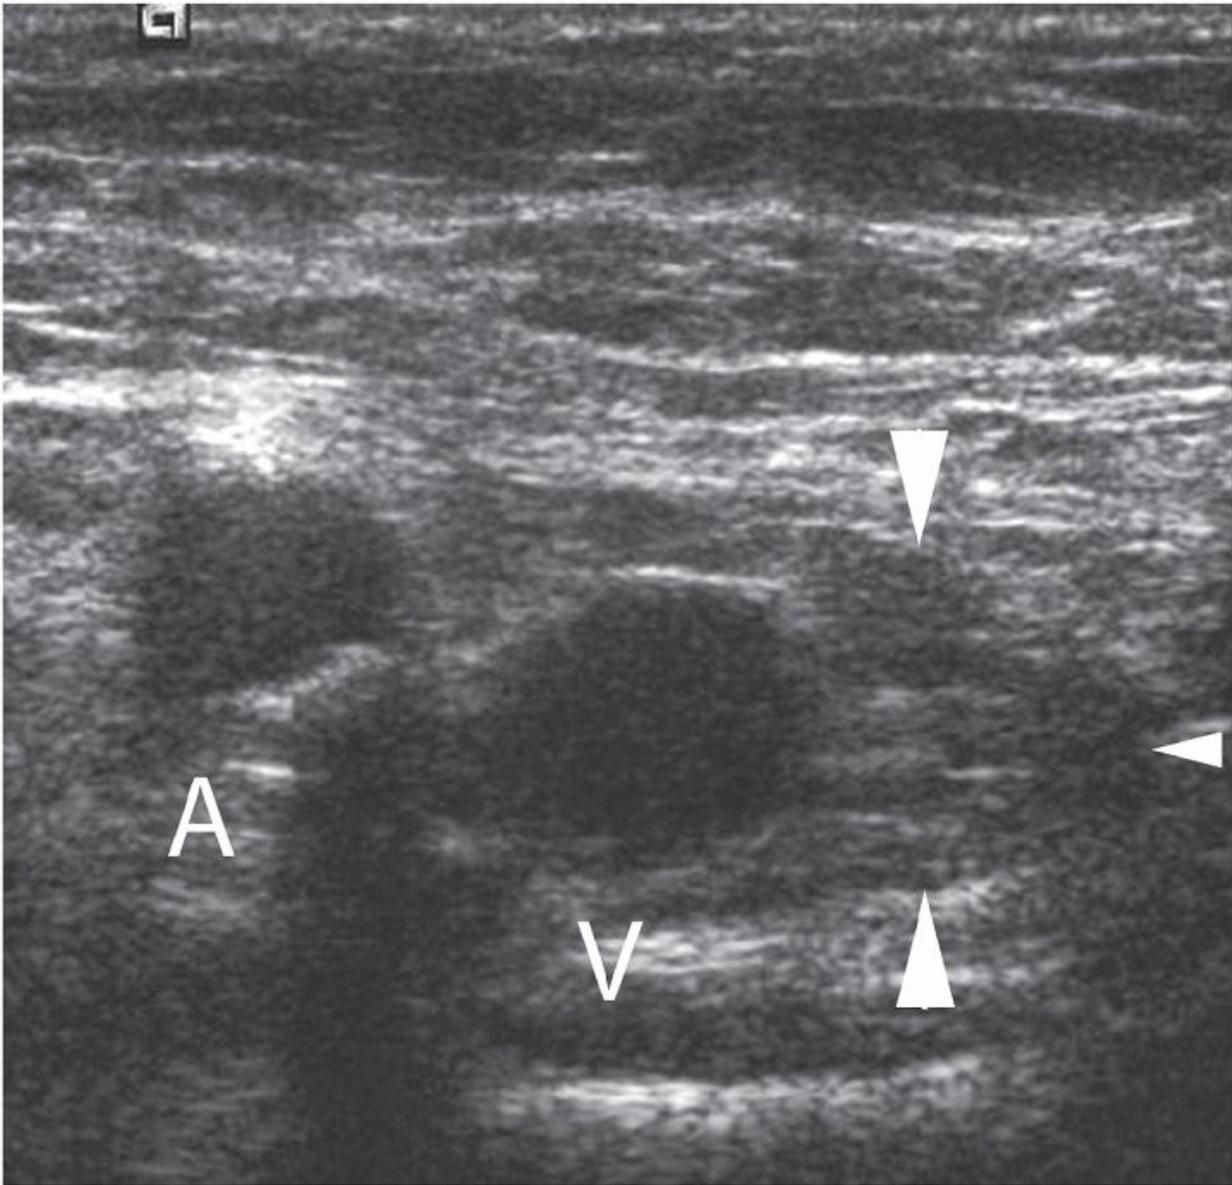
Femoral hernia. Transverse sonogram during Valsalva shows femoral hernia (arrowheads) medial to the femoral vein (V) and artery (A).
